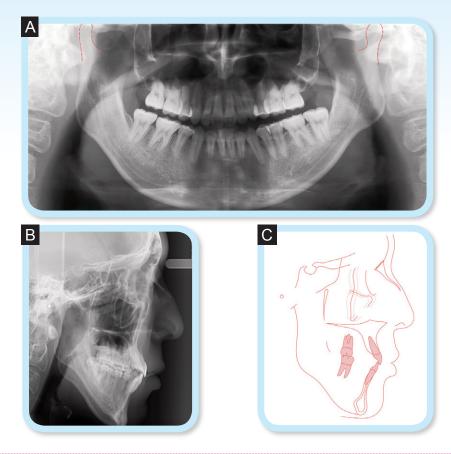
Post-treatment radiographs and tracing: A, panoramic radiograph B, lateral cephalogram C, cephalometric tracing
